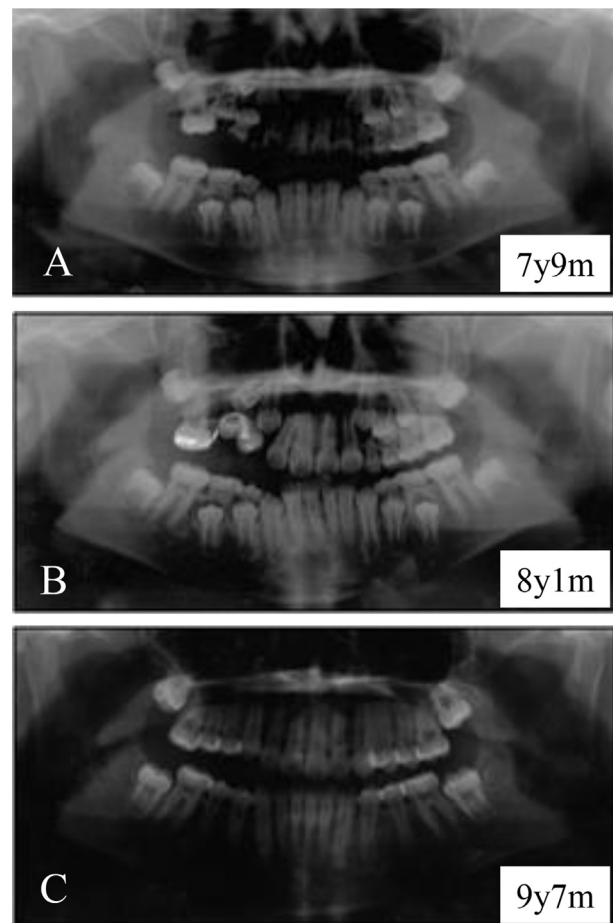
Panoramic radiographs: (A) pretreatment (7 y 9 m), (B) uprighted upper right first molar (7 y 11 m), and (C) after initial treatment of the right posterior teeth.
